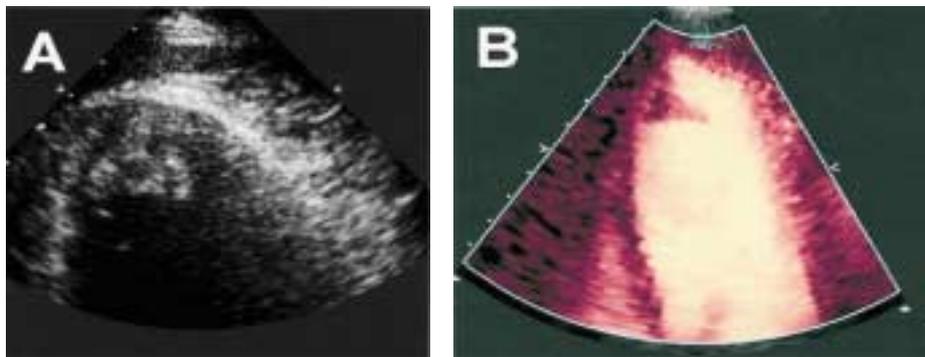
A: two-dimensional apical 4-chamber view with apex magnification demonstrating a reduction in the size of the thrombotic mass recorded 8 days later. B: at harmonic power Doppler mode after Levovist injection the thrombus appeared clearly reduced in size and, due to thrombus mass excavation, its morphology changed from laminar to pedunculated.
